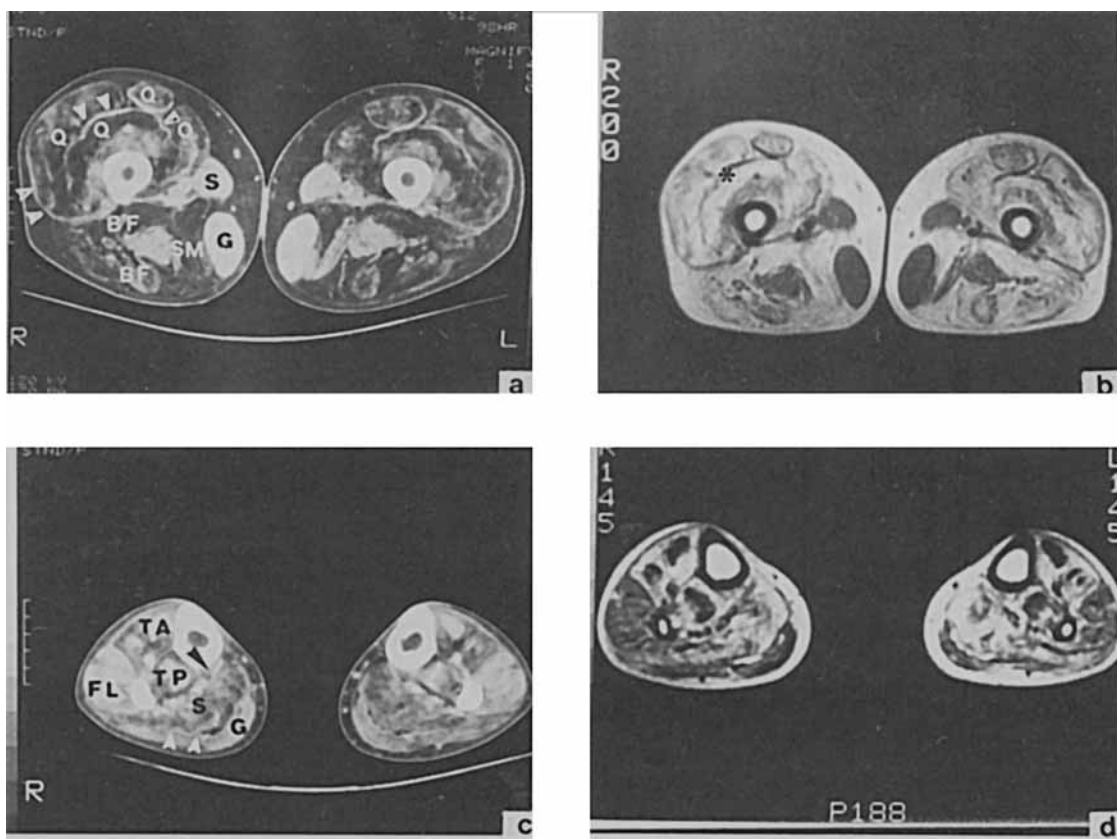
(a) Midthigh CT scans showing symmetrical and predominant involvement of both quadriceps (Q) and biceps femoris (BF) muscles with relative sparing of gracilis (G), sartorius (S), and semimembranosus (SM) muscles; (b) midthigh MRI scans showing affected muscles as relatively hyperintense with a signal comparable to that of subcutaneous fat (*); (c) note the predominant and symmetrical involvement of the posterior and medial compartment of the legs with affected soleus (S) and gastrocnemius (G) and spared tibialis anterior (TA), tibialis posterior (TP), and fibularis longus (FL). The peripheral rim due to epimysial connective tissue is indicated (arrow-heads) both in a and c; (d) MRI T1-weighted images show affected muscles as hyperintense.
